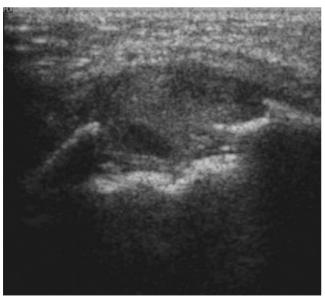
Ultrasonograms of the mandible show a soft tissue mass arising from cortex of the mandible with cortical destruction.
